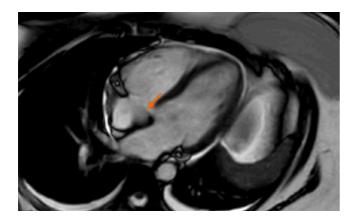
Cardiac magnetic resonance imaging showing an enhancing lesion near the septal leaflet of a tricuspid valve (orange arrow).
